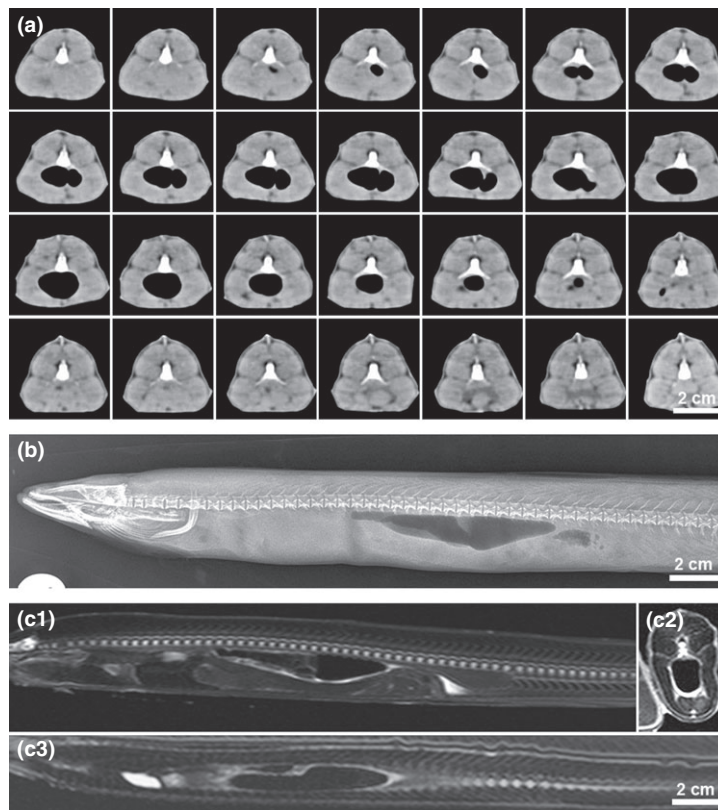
Anguilla anguilla*, no. 5. (a) Computed tomography showing a clearly discernible parasite-free swimbladder. (b) Lateral radiograph of the cranial half of the same eel with a distinct radiographic shadow of the swimbladder and no visible worms. (c1) Lateral, (c2) transverse and (c3) dorsal T2 MRI images of the same eel showing a clearly visible parasite-free swimbladder in all three views.
